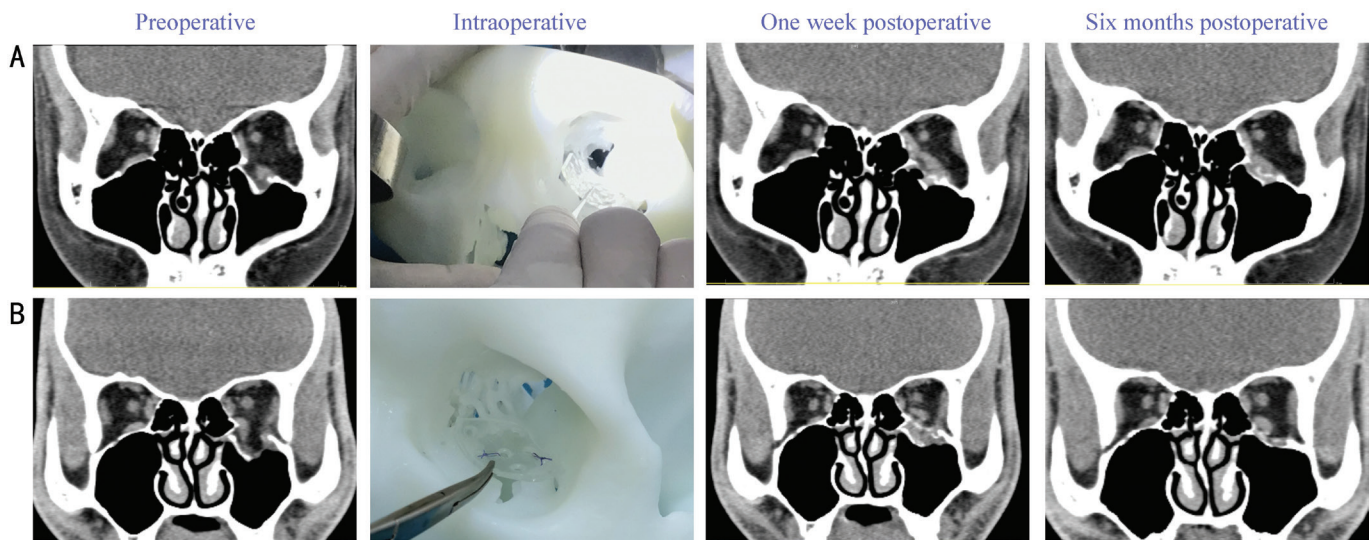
Coronal CT images of volunteers A and B before the surgery, 1wk, and 6mo after the surgery. It also shows the utilization of absorbable materials combined with 3D printing models to aid in orbital fracture repair during the operation. CT: Computed tomography.
